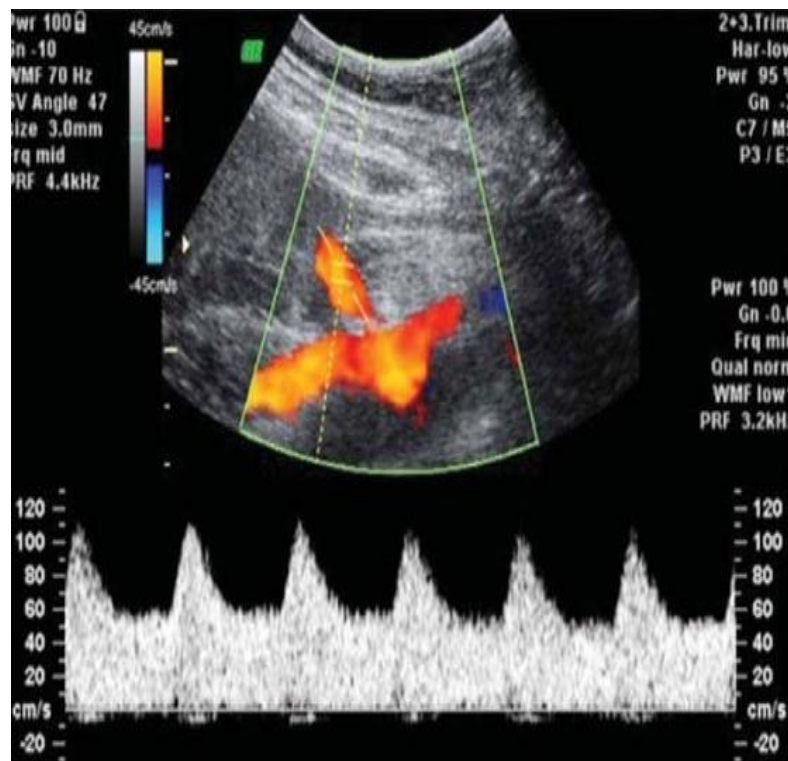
NORMAL UTERINE ARTERY DOPPLER
